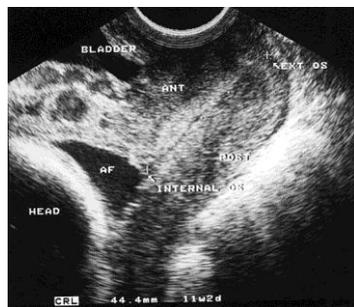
Transvaginal ultrasound scan showing a relatively long cervix measuring 44.4mm in length. This case delivered at term.
